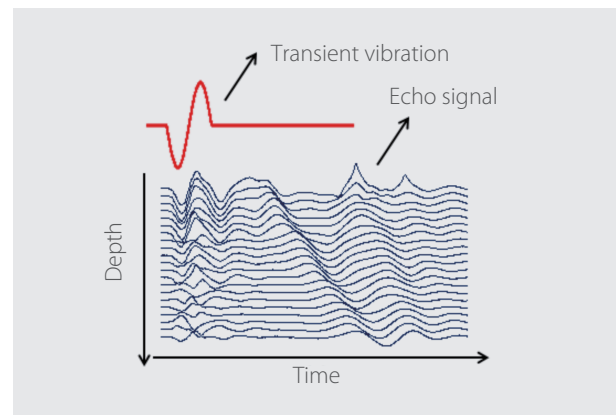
Tracking of Shear Wave Propagation by Using Ultrasonic Signals
